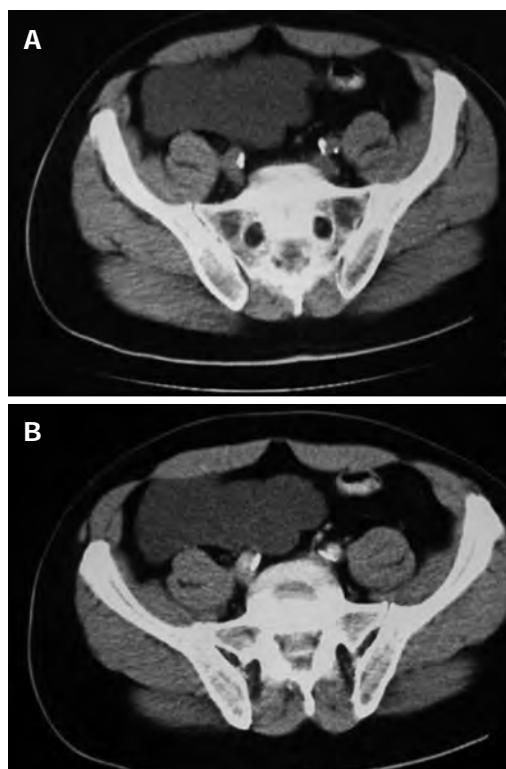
Computed tomography axial image results. A: Plain computed tomography axial image showing a hypodense mass; B: Contrast enhancing computed tomography axial image demonstrating an intra-peritoneal hypodense non-enhancing tumor.
